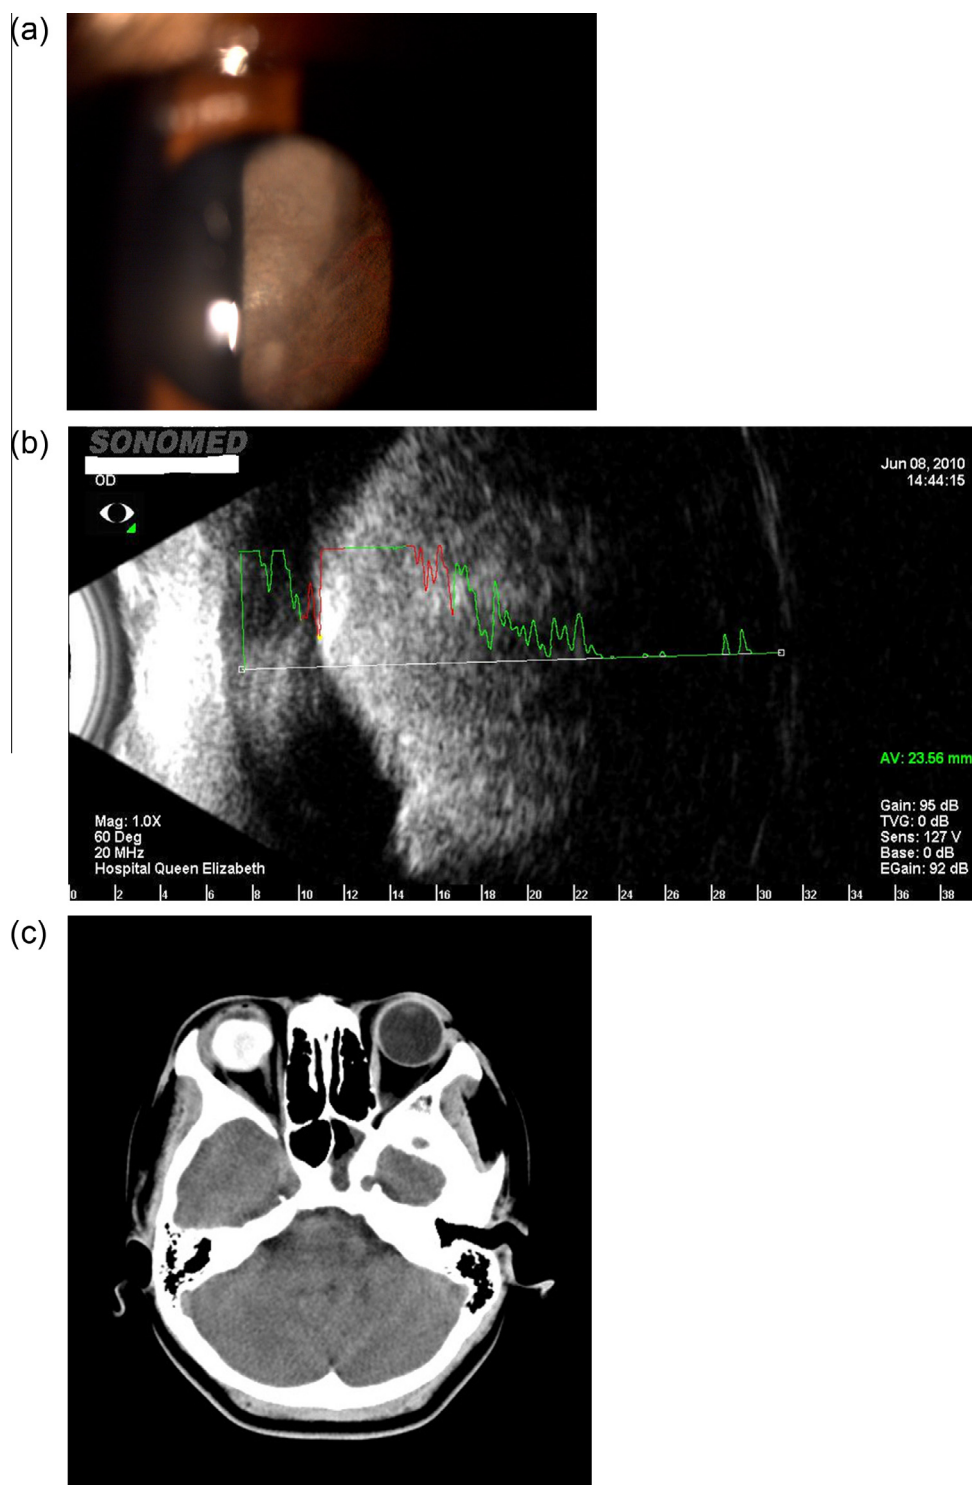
(a) Slit-lamp image of the right eye, showing the retrolental tumor. (b) Ultrasound image showing the huge choroidal tumor, with areas of high internal reflectivity. (c) CT-scan image shows the 12mm × 20 mm intraocular tumor without any extension.
